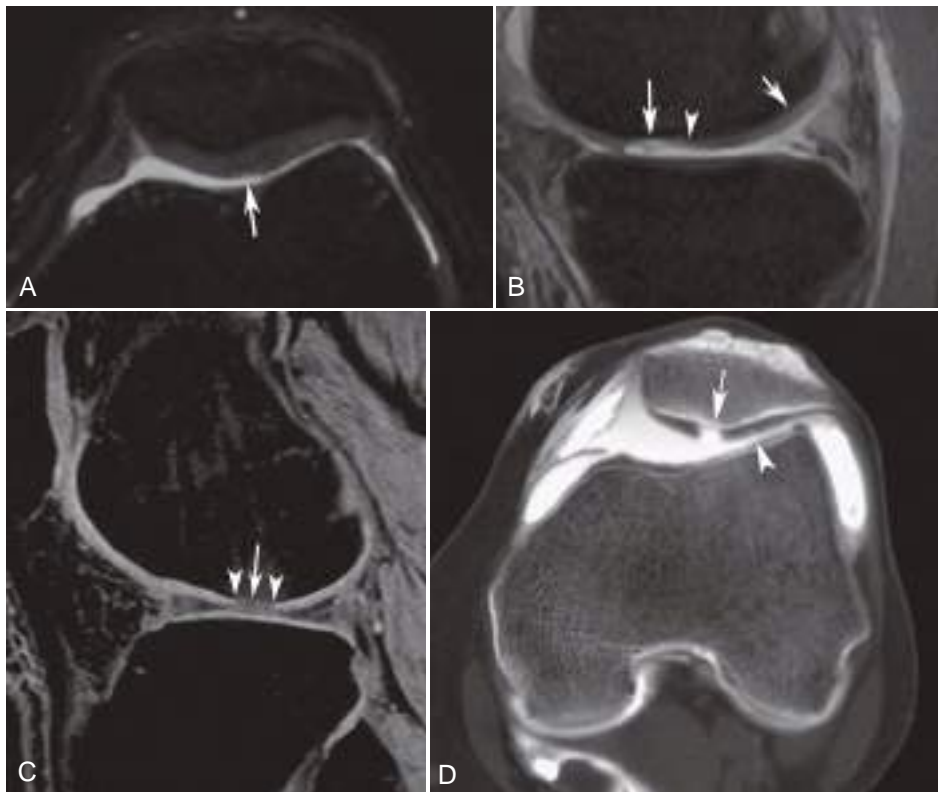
Articular cartilage defects. (A) Axial fat-suppressed fast spin-echo T2-weighted MR image (echo time, 42 msec) shows grade 1 or shallow grade 2 defect of the median ridge of the patella (arrow). (B) Sagittal fat-suppressed fast spin-echo T2-weighted MR image (echo time, 60 msec) of the knee shows grade 4 (long arrow) and grade 2 (arrowhead) defects of the lateral femoral condyle. Contrast this with the normal cartilage more posteriorly (short arrow). (C) Sagittal fat-suppressed spoiled gradient-echo MR image shows grade 4 defect of the lateral femoral condyle (arrow). The arrowheads mark the margins of this sharply marginated cartilage defect. (D) Axial computed tomographic arthrogram of the left knee shows grade 4 defect of the medial patellar facet (arrow). Also note small, grade 1 defect of the lateral patellar facet (arrowhead).
